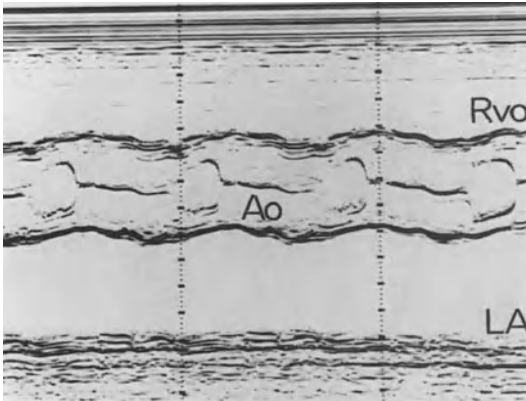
Echocardiogram of the aortic root. The right ventricular outflow tract (RVO) lies anteriorly and the left atrium (LA) posteriorly. Between the anterior aortic wall (AAW) and the posterior wall (PAW), the typical “box-like” opening movements of the right and noncoronary cusps of the aortic valve are demonstrated.
